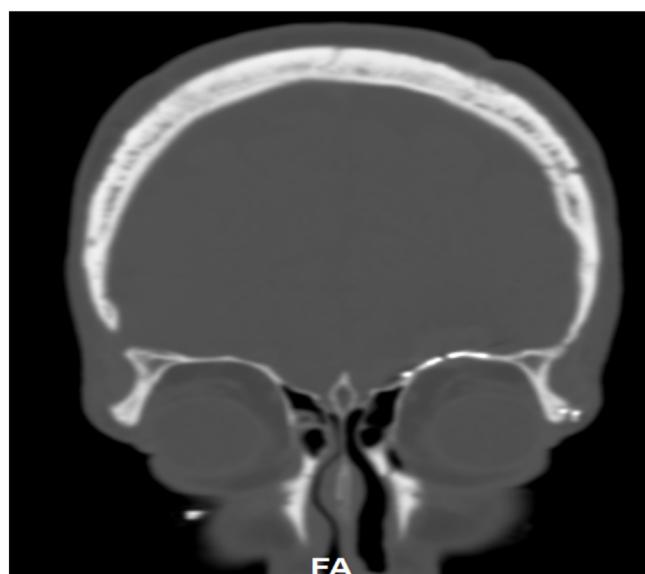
Post-operative CT scan. Cranioplasty mesh is now positioned over a left orbital roof fracture and elevation of fracture fragments. Intra-orbital extra coronal hematoma is stable.
